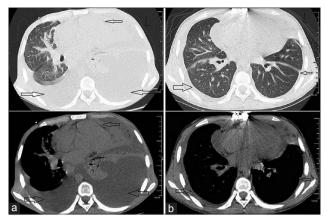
Comparison of thoracic computed tomography images before and after operation. (a) Preoperative thoracic computed tomography showing bilateral massive pleural effusions, thickness of the pericardium (arrows). (b) Postoperative computed tomography revealing a little thoracic cavity hydrops (arrows).
